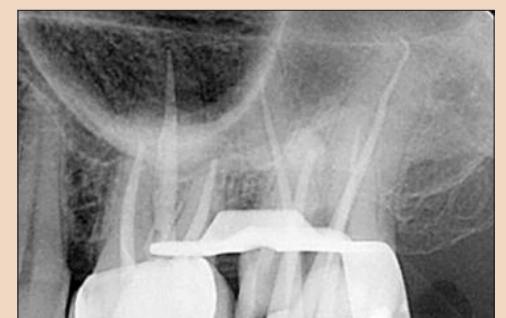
Conefit Radiograph
